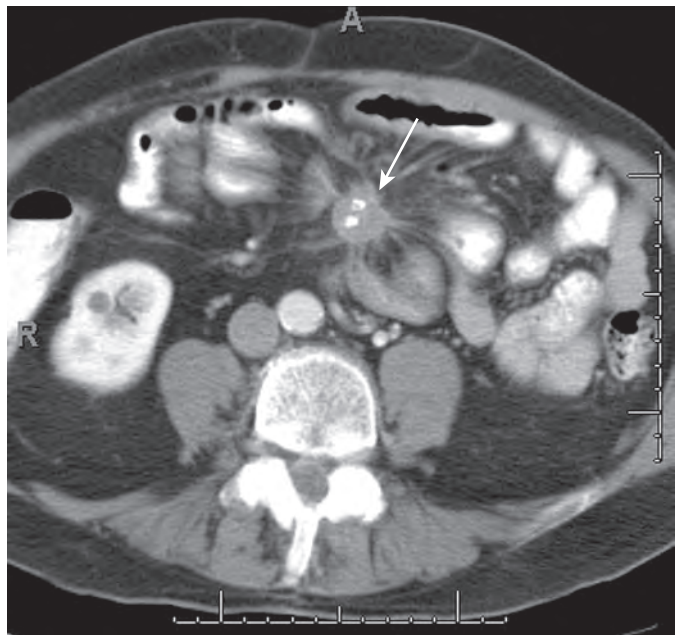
Carcinoid tumor. Axial CT in a patient with metastatic carcinoid tumor of the small bowel to the mesenteric nodes (arrow). This metastatic node causes a desmoplastic reaction with radiating strands into the mesentery.
